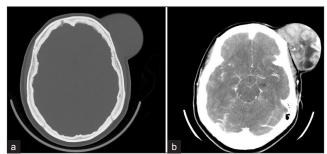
27-year-old with DFSP. Axial CT head (a) without and (b) with contrast demonstrate a large protuberant soft tissue mass arising from the left frontal scalp. The mass enhances heterogeneously after contrast with areas of central hypovascularity but no invasion of the calvarium.
